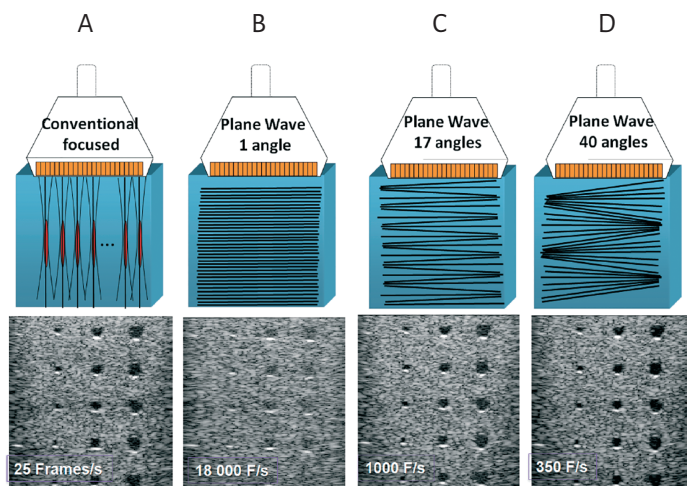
Conventional focused and ultrafast ultrasound imaging sequences (4-cm deep region of interest): (a) conventional focused imaging, (b) plane-wave imaging, (c) plane-wave compounding with 17 angles, and (d) plane-wave compounding with 40 angles. [Adapted from Tanter et al.³⁴]
